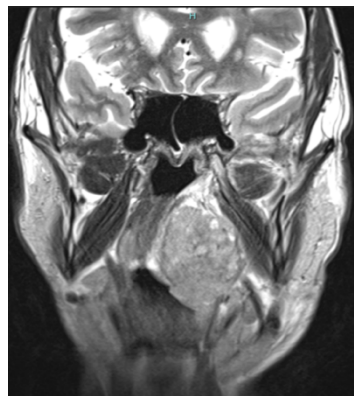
MRI coronal section before chemotherapy.
